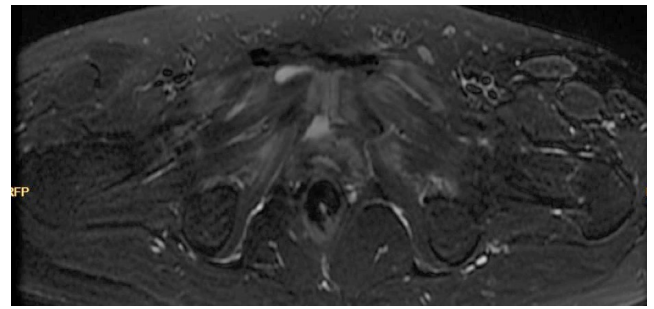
Axial T2-section of MRI showing bilateral bone marrow edema, periarticular edema and low grade adductor strain.
